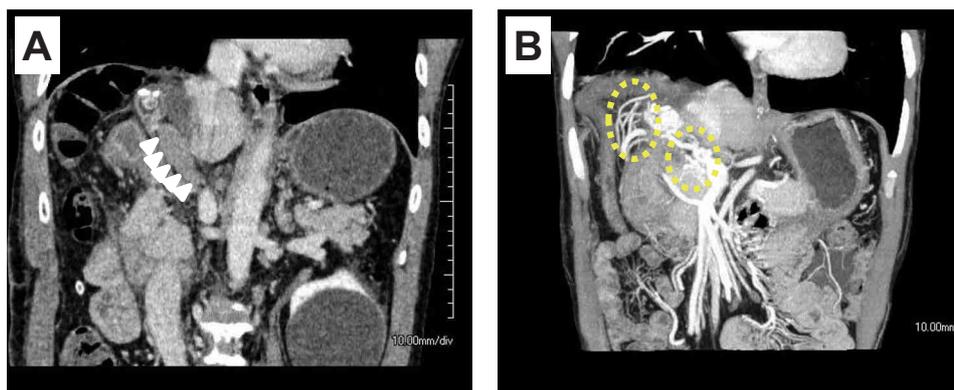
(A) CT on postoperative day 3. Thrombus of the portal vein was detected (arrowheads). (B) CT on postoperative day 8. Collateral vessels (yellow dotted circles) formed around the hepatoduodenal ligament. CT computed tomography.
